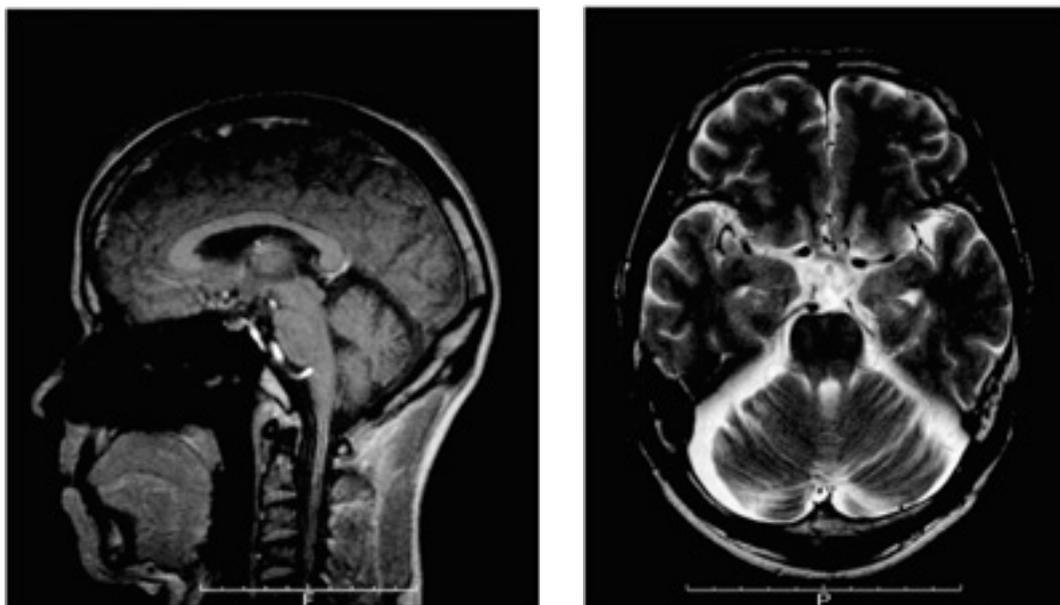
Brain MRI showing atrophy of the cerebellum without brainstem involvement
